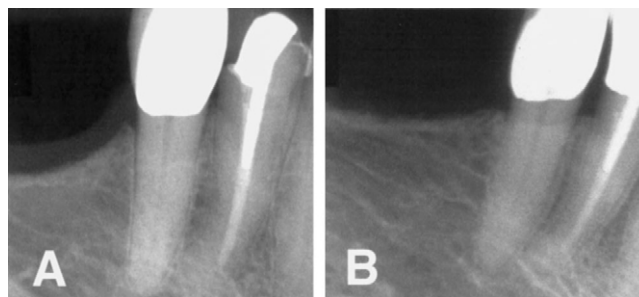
Radiographs of the mandibular right first premolar with a perforation at the apical region of the mesial root. A, Postoperative radiograph taken immediately after the repair of the perforation. B, Radiograph taken 15 months after perforation repair.
